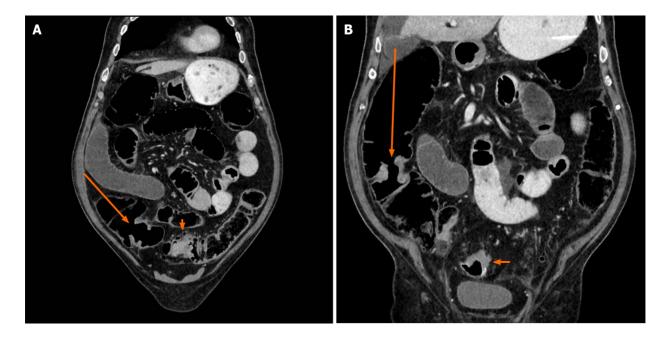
Coronal contrast-enhanced computed tomography image. A: The proximal right colonic tumor (long arrow) at the level of the ileocecal valve, evidenced by a focal mild circumferential wall thickening. Sigmoid cancer is partially seen (short arrow); B: The middle right colonic tumor (long arrow), evidenced by a focal circumferential wall thickening without obstruction. Sigmoid cancer is partially seen (short arrow).
